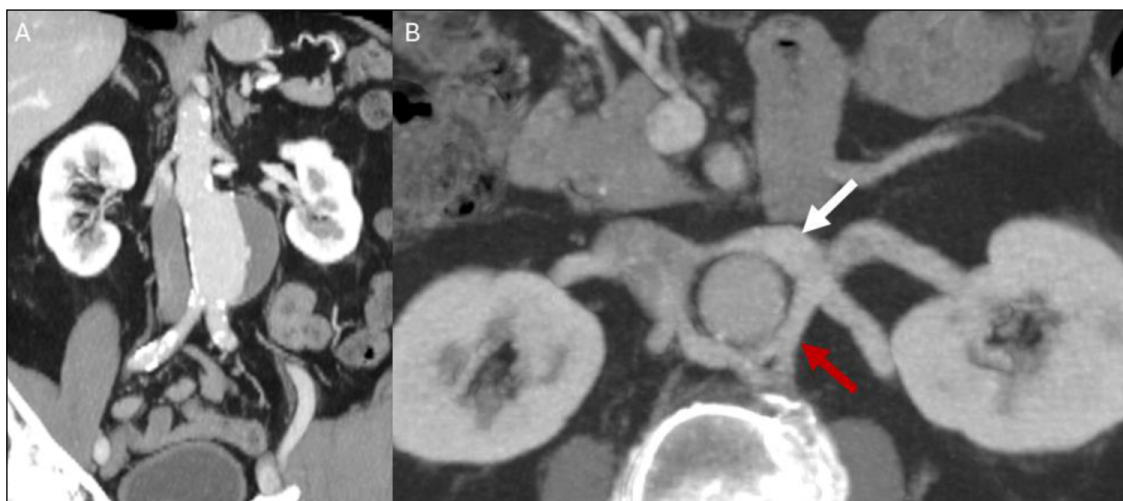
Preoperative computed tomography angiography of the patient. (A) Coronal maximum intensity projection (MIP) image shows a 6 cm infrarenal abdominal aortic aneurysm; (B) axial MIP image shows preaortic (white arrow) and retroaortic branches (red arrow) on the left renal vein.
